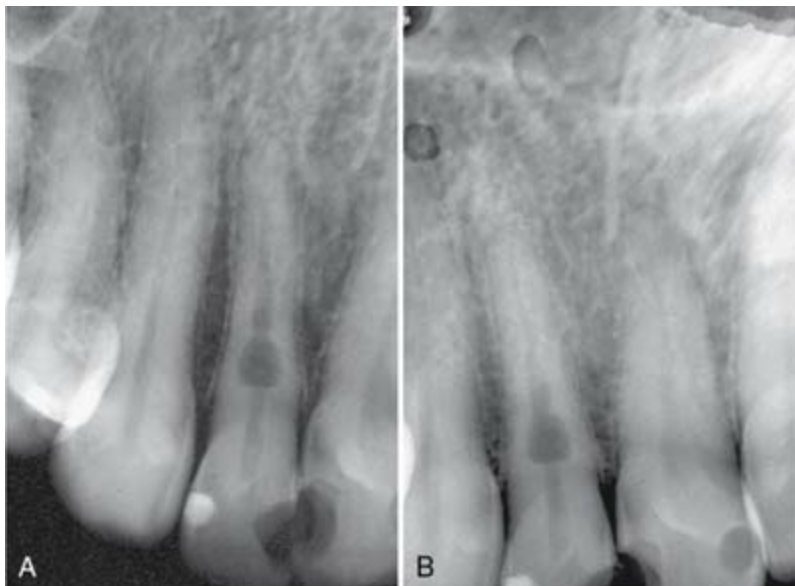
Angled radiographs to show internal resorption. Radiographs from two different horizontal projections depict (A) the lesion within the confines of the canal on both views and (B) the adjacent bone intact on both views.
